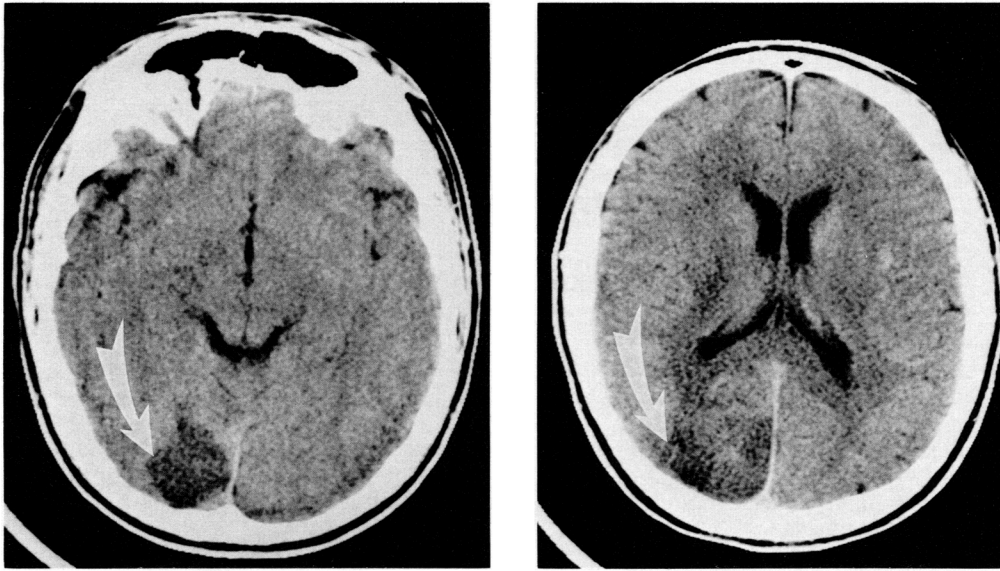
Admission computed tomographic scan of patient showing evidence of a right occipital infarction (arrow).
